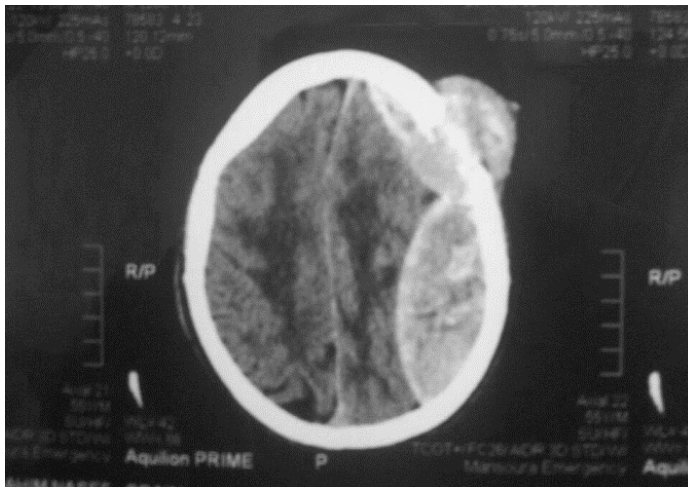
Pre-operative CT brain explaining large EDH with bony erosion and extra dural lesion
